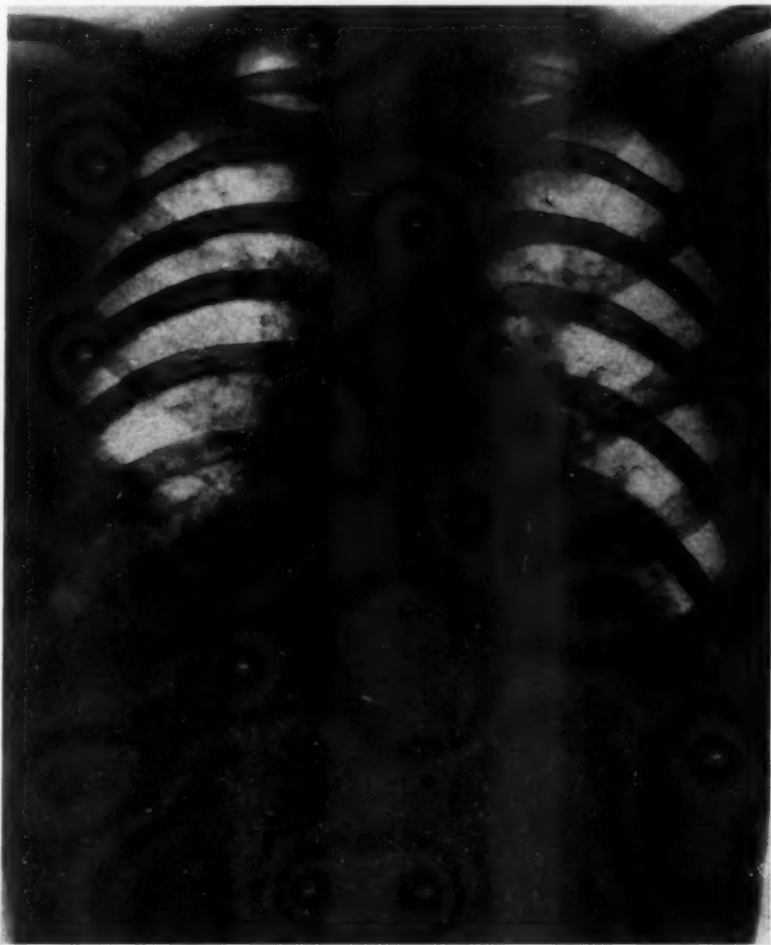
Roentgenogram (September 7). Increase in densities at both bases.
